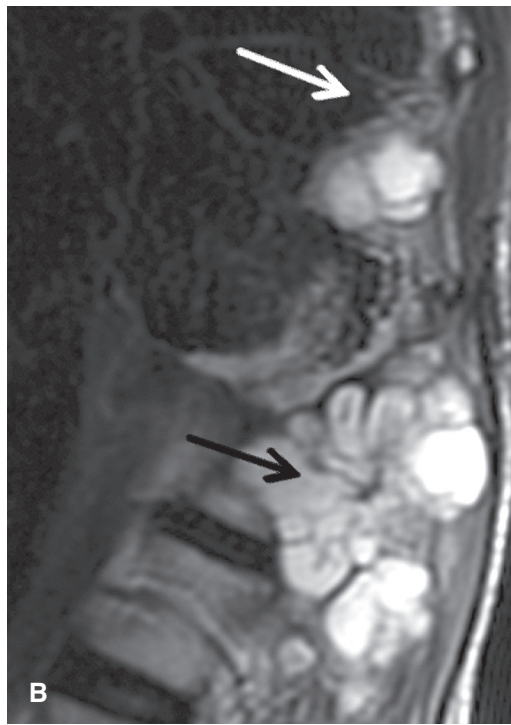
A 48-year-old woman with large, invasive thoracic spine chordoma. *A:* Sagittal, T1-weighted MR image shows bulky low-signal soft-tissue mass involving T12 vertebral body (*arrow*) extending into posterior elements and replacing normal bone marrow. *B:* Sagittal, T2-weighted MR image shows high-signal chordoma of T12 vertebral body (*black arrow*) with mass effect on right neural foramen. Paraspinal component extends cranially beyond image margins (*white arrow*).
